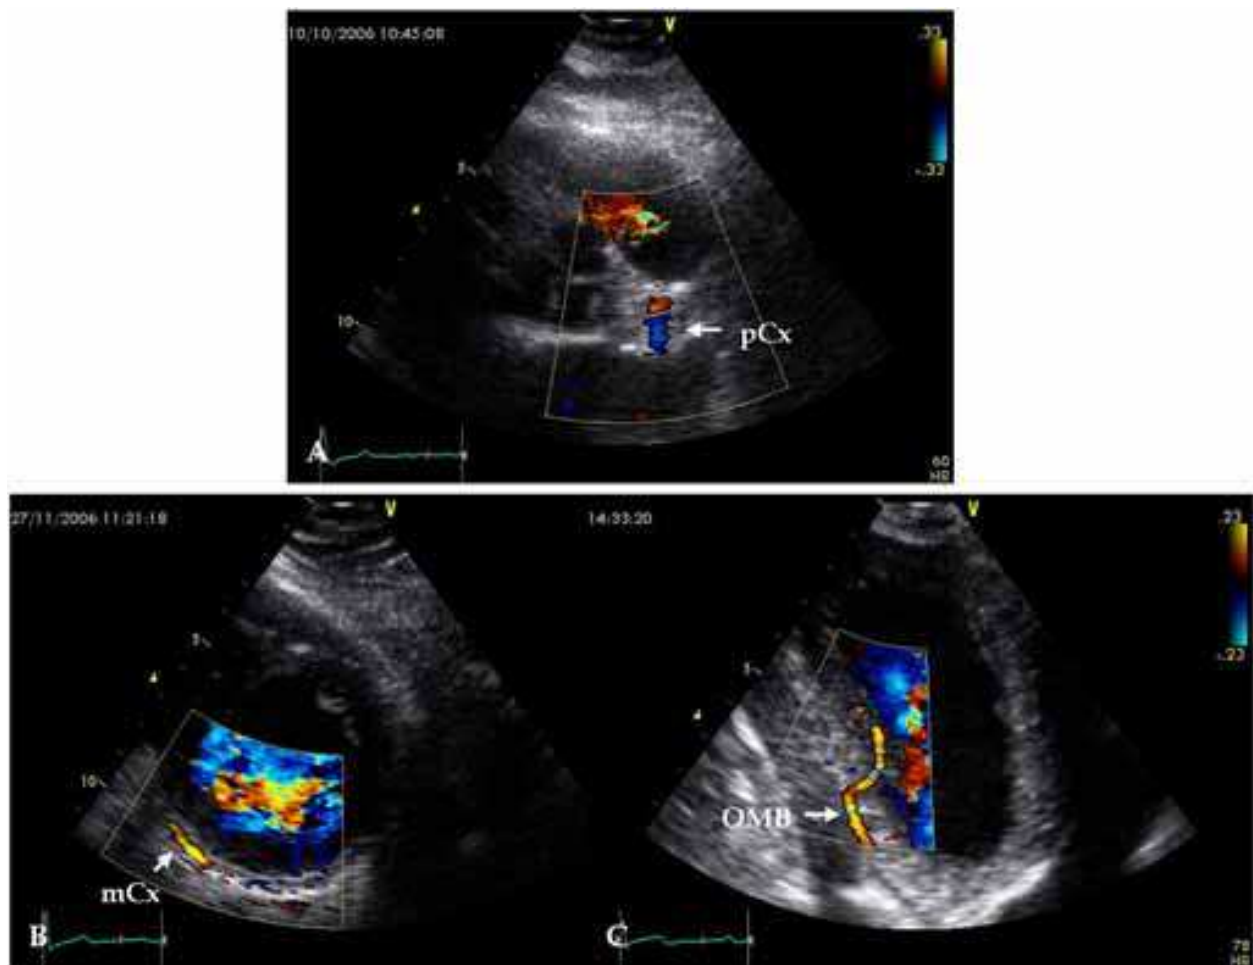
Color Doppler images of the Cx, Nyquist limit is 20-33 cm/s. A – proximal Cx (pCx); the left parasternal position, a modified parasternal short-axis view of great vessels; B - mid Cx (mCx); the left parasternal position, a modified parasternal short-axis view at the level of papillary muscles; C – the first obtuse marginal branches (OMB) presenting distal Cx, the apical long-axis position, a modified five-chamber view.
